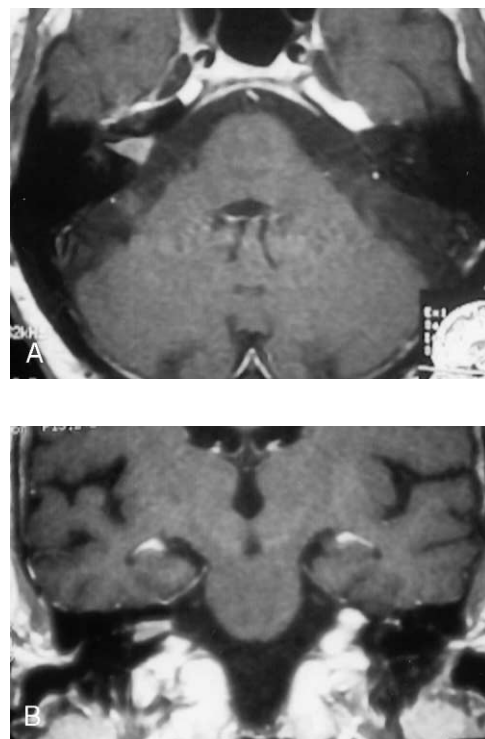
Axial (A) and coronal (B) MR T1-weighted images with gadolinium showing an intracanalicular mass slightly extending to the cerebellopontine angle. A preoperative diagnosis of intracanalicular meningioma was suspected on the basis of the broad base shape of the CPA portion of the tumor [Case 5].
